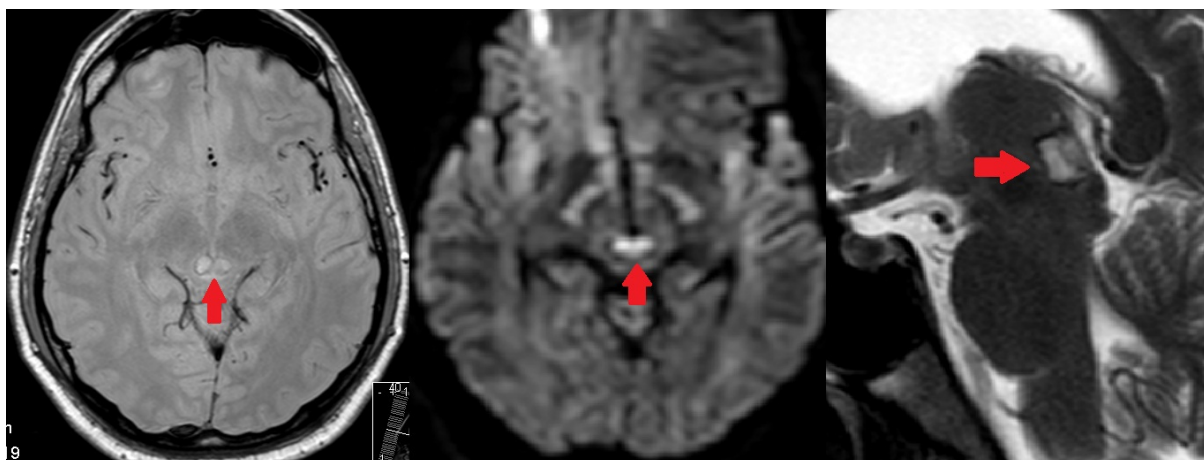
T2, diffusion weighted MRI and apparent diffusion coefficient map demonstrate acute infarction in the upper most part of the midbrain.
